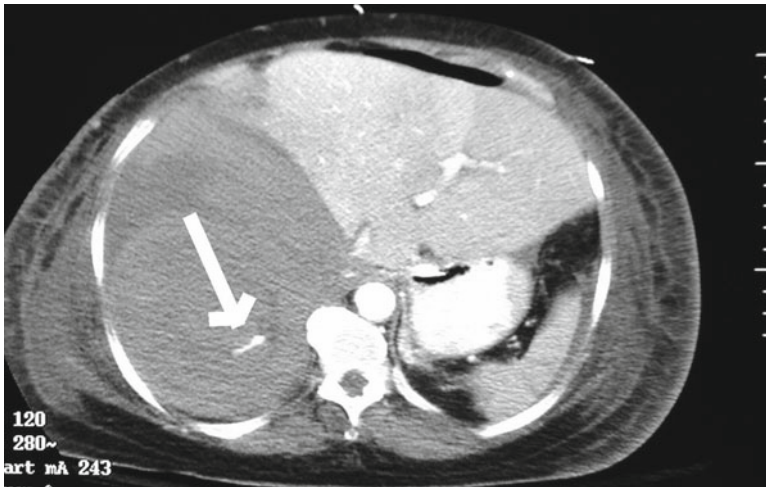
CT scan appearance of RPH following biopsy of the kidney. Note acute extravasation of the contrast denoting brisk bleeding
